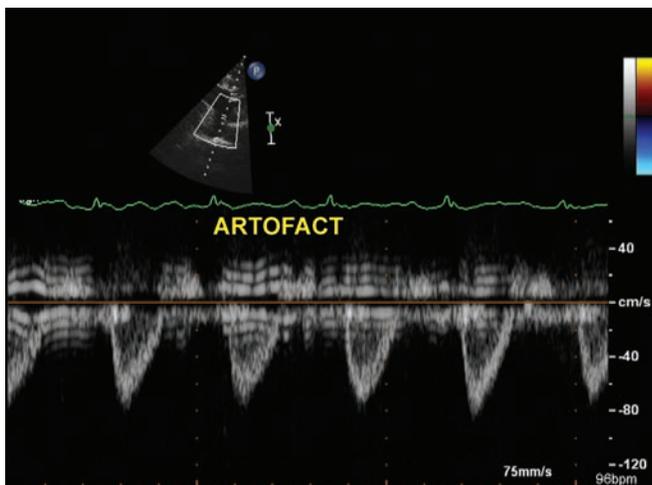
Doppler artifact produced during pulsed wave interrogation of the proximal descending aorta.
